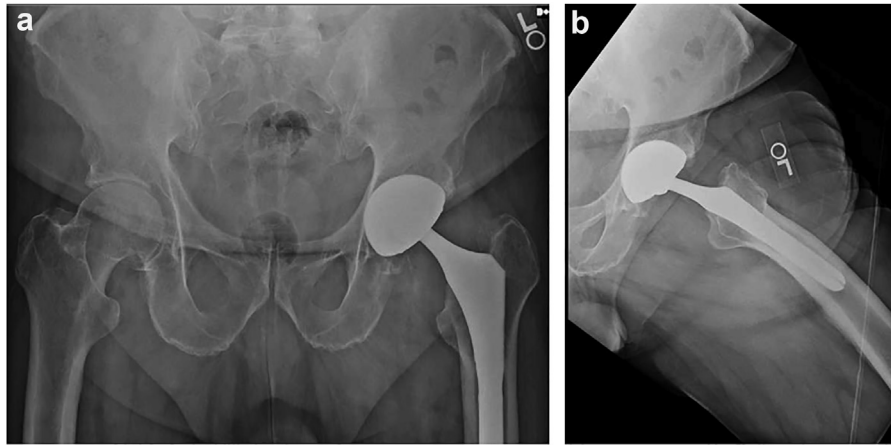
(a and b) Postoperative anteroposterior and cross-table lateral radiographs 1.5 years following initial arthroplasty demonstrating well-positioned components.
